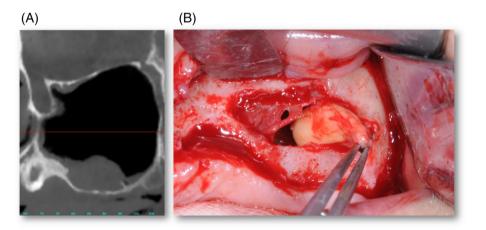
(A) Pre-op CBCT, (B) Solid "cheese-like" cyst surgically removed.
